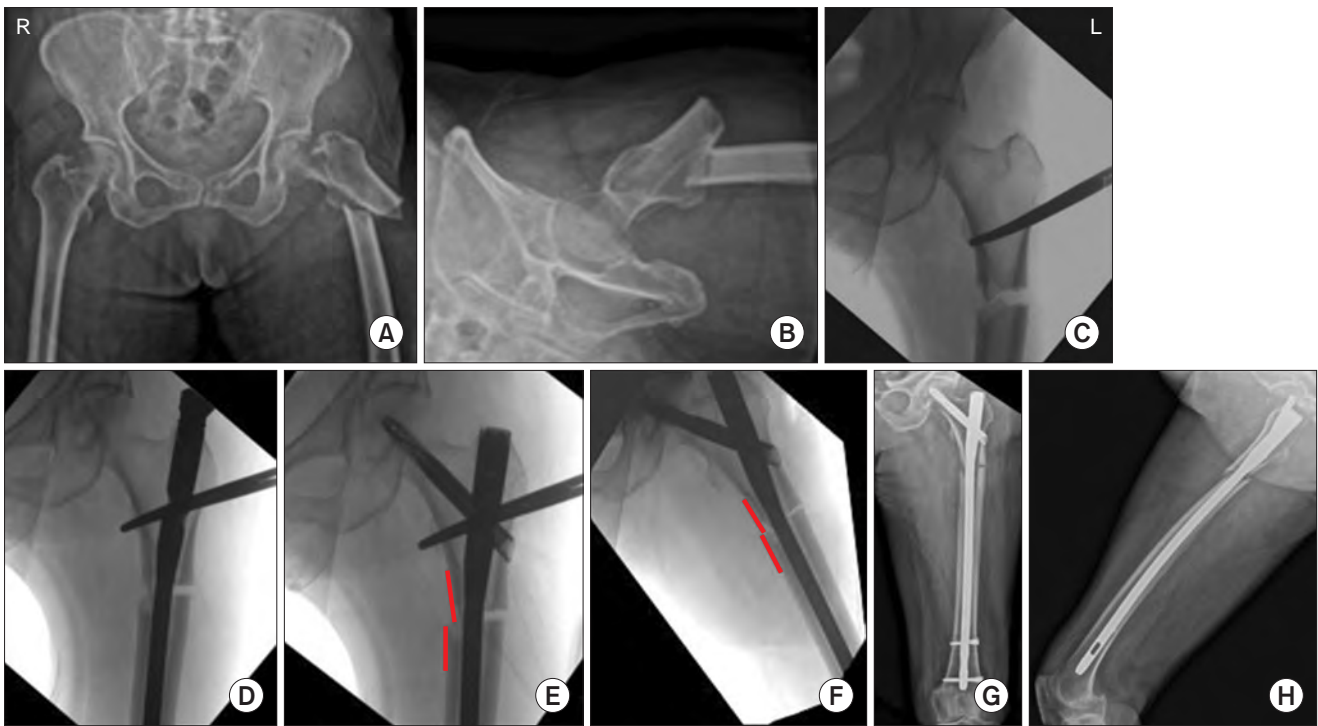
A 92-year-old female patient sustained a left atypical subtrochanteric fracture following a ground level fall. Preoperative hip anteroposterior (A) and lateral (B) plain radiographs revealed a transverse pattern of fracture corresponding to 32A3 in the AO/OTA classification. (C) A minimally invasive reduction technique using long Kelly forceps was performed to correct the flexion and external rotation deformity of the proximal fragment and restore alignment, but residual varus alignment was observed after reduction. (D) An intramedullary nail was inserted and cephalomedullary fixation was performed with 1 helical blade. (E, F) Intraoperative C-arm anteroposterior image before and after hip abduction showed correction of the varus alignment and reduction of the residual gap. The medial cortex (red lines) of the proximal and distal fragments changed from varus to near-neutral alignment. (G, H) Postoperative femur anteroposterior and lateral plain radiographs. Alignment was well restored and high reduction quality was achieved.
